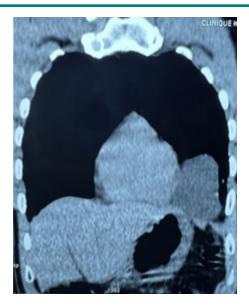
Chest CT scan (frontal section) Paracardiac fluid mass.
